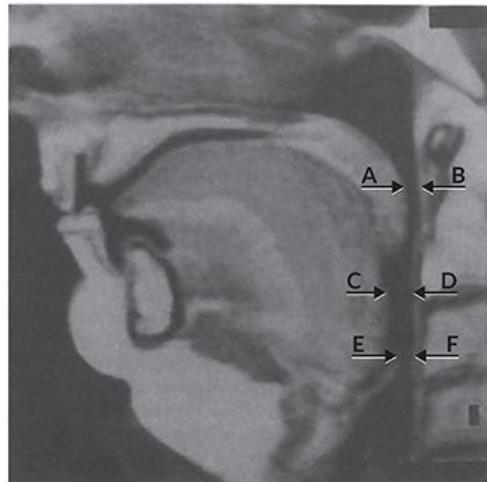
Sagittal magnetic resonance imaging of the upper airway of an awake patient. A-B is the junction of nasopharynx with velopharynx, C-D is the retroglossal pharynx, and E-F is the minimum anteroposterior upper airway diameter at the tip of the epiglottis. The laryngopharynx extends downward from E-F to the cricoid cartilage. *Reprinted with permission from Shorten GD, Opie NJ, Graziotti P, et al. Assessment of upper airway anatomy in awake, sedated and anaesthetised patients using magnetic resonance imaging. Anaesth Intensive Care. 1994;22(2):165-169. Copyright © 1994 SAGE Publications.*
